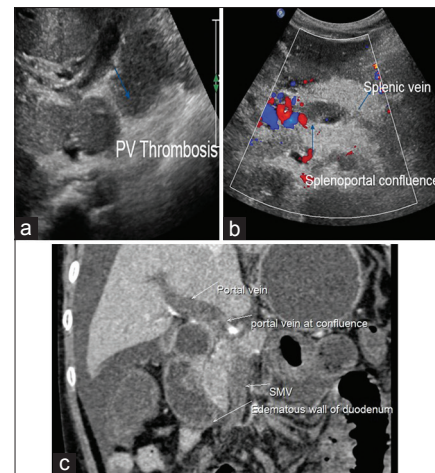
(a) Gray scale image of Case 2 showing portal vein thrombosis, (b) Doppler showing thrombosis of splenic vein and splenoportal confluence, and (c) computed tomography angiography showing noncontrast filling of portal vein, splenoportal confluence, and superior mesenteric vein with edematous wall of duodenum
